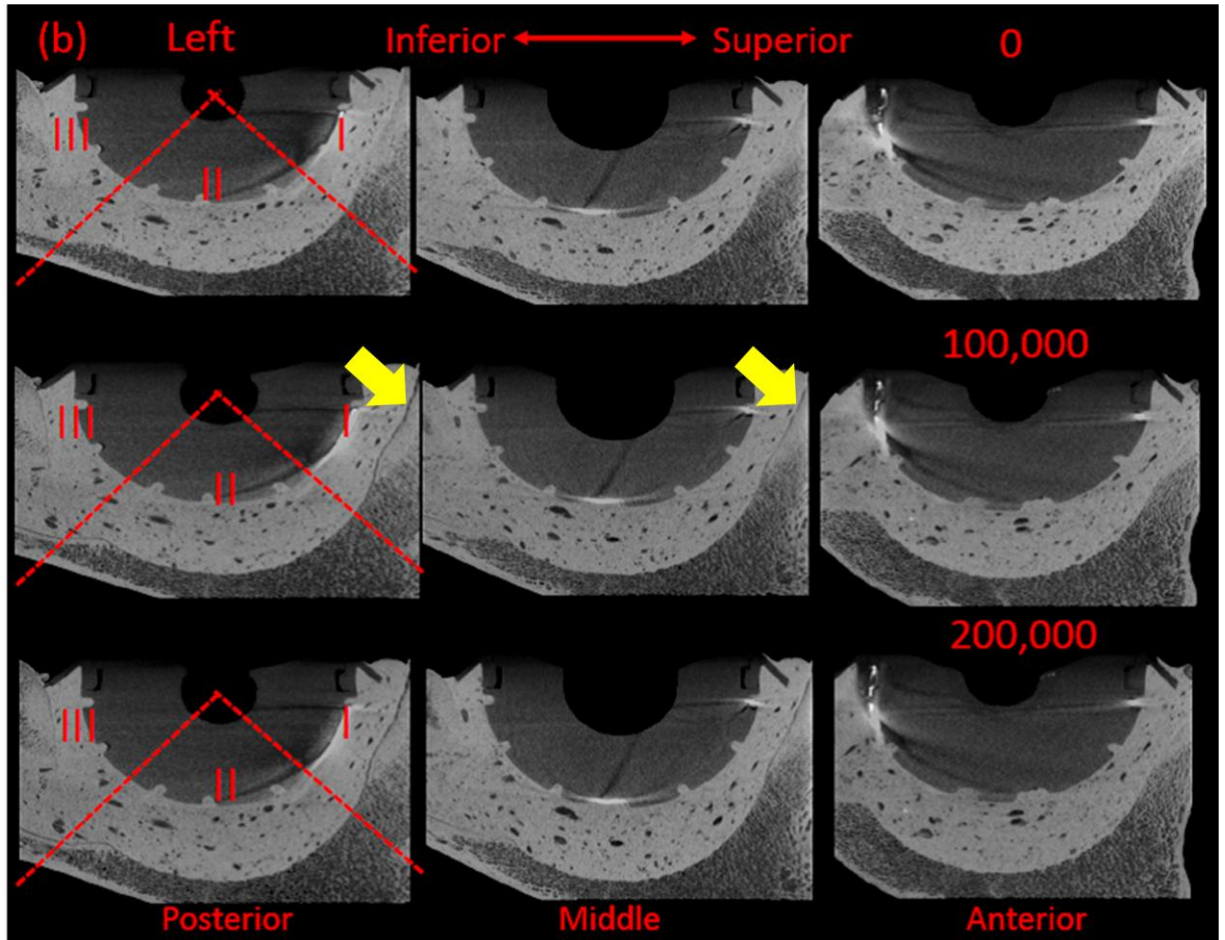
7: μ CT sectional reconstructions recorded at selected loading intervals for (a) right and (b) left implanted hips. The images are shown with the DeLee & Charnley zones identified. For both samples, the bone-cement interface appeared to be intact prior to testing. Interfacial debonding between the bone and the cement seemed to initiate in zone I in the superior quadrant, as indicated by the arrows (Tozzi et al., 2012).
